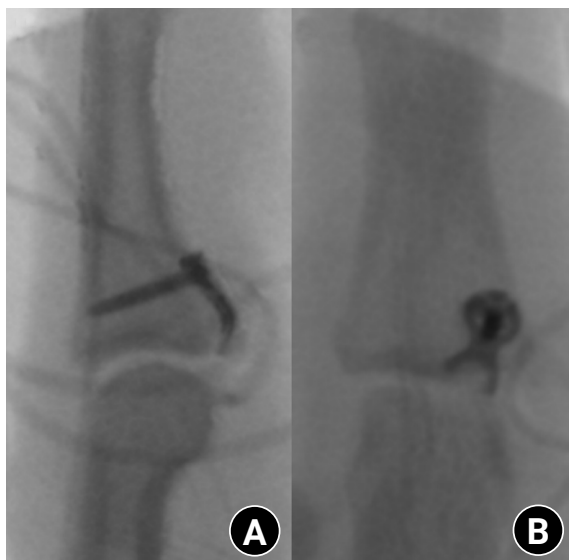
Radiographs after hook plate fixation. (A) Lateral view. (B) Anteroposterior view showing the hook plate crossing the fracture line and secured with a distal screw.
